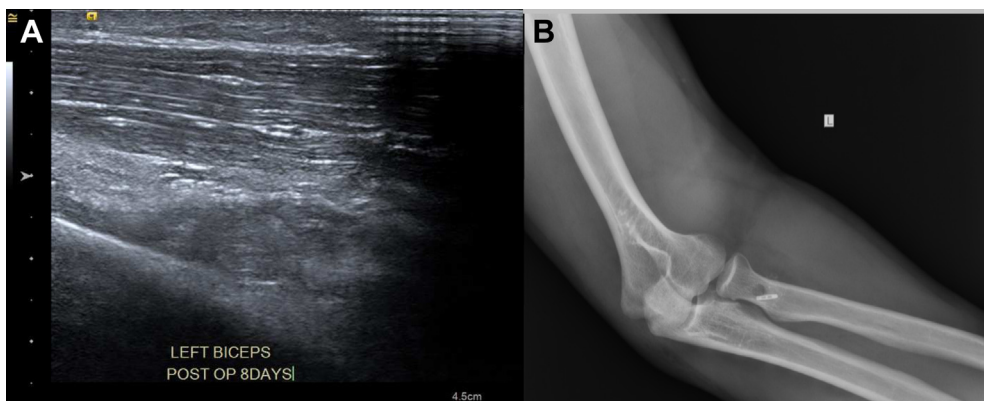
(A) Ultrasound image postop showing the reattached biceps tendon filling the tendon sheath at the site of insertion, (B) postop x ray of the elbow.
